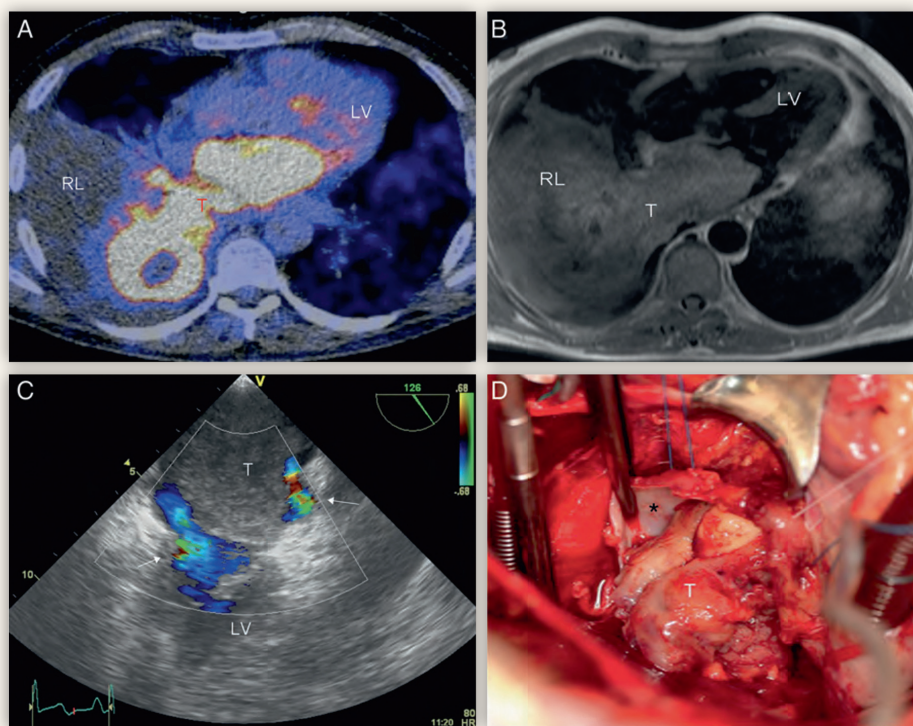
(A) FDG (fluorodeoxy-glucose-18) PET-CT scanning (transverse section, four-chamber view) revealed hypermetabolic uptake of FDG in the tumour, consistent with malignancy. (B) Static cardiac MRI imaging did not provide complete information concerning the attachment of the tumour (T) along its tracking into the wall of the pulmonary vein. RL: right lung; LV: left ventricle. (C) The presence of flow at Doppler between the mass and the wall of the left atrium (white arrows) suggests the absence of tumour invasion. (D) The intraoperative detachment of the tumour (T) from the inferior pulmonary vein (*), at the level of the ostium in the left atrium
